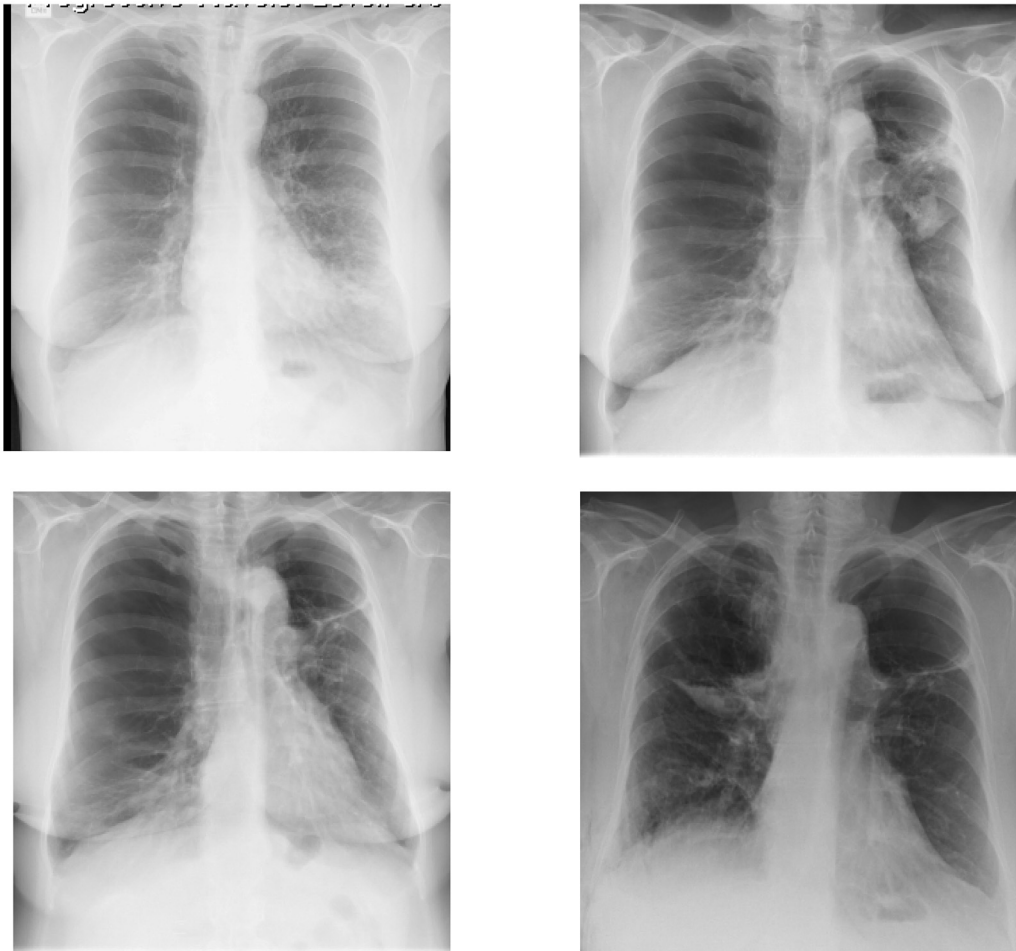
Serial chest X-rays. A) Pre-all procedures. B) Early post-left upper lobe bronchoscopic lung reduction. C) Late post-left upper lobe bronchoscopic lung reduction. D) Early post-right upper lobe surgical lung reduction. Note movement of mediastinum and changing volume of lower lobes.
